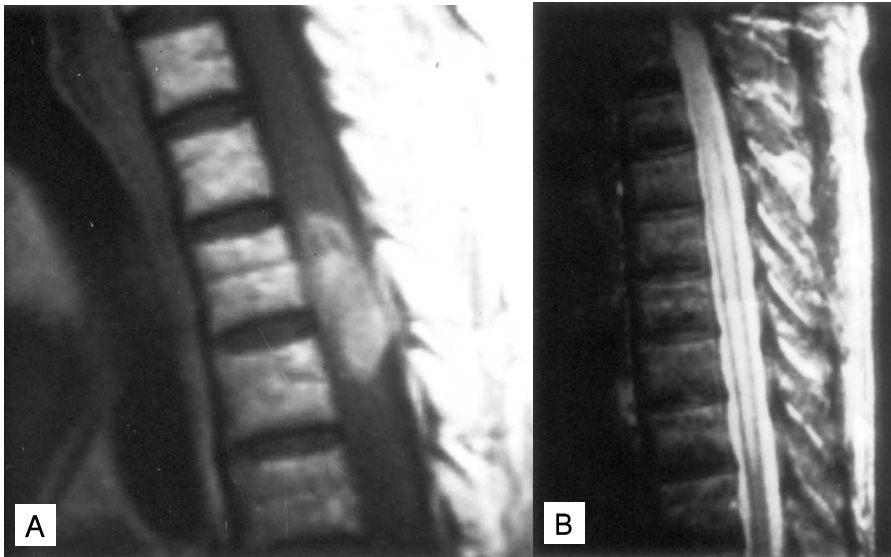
A) Gd-enhanced sagittal T1-weighted MR image revealed strongly enhanced intramedullary spinal cord mass at the levels of T3 and T4 in Case 1. B) T2-weighted sagittal MR image showed enlarged spinal cord with central high signal intensity in the mid-thoracic area suggesting syringomyelia in Case 1.
